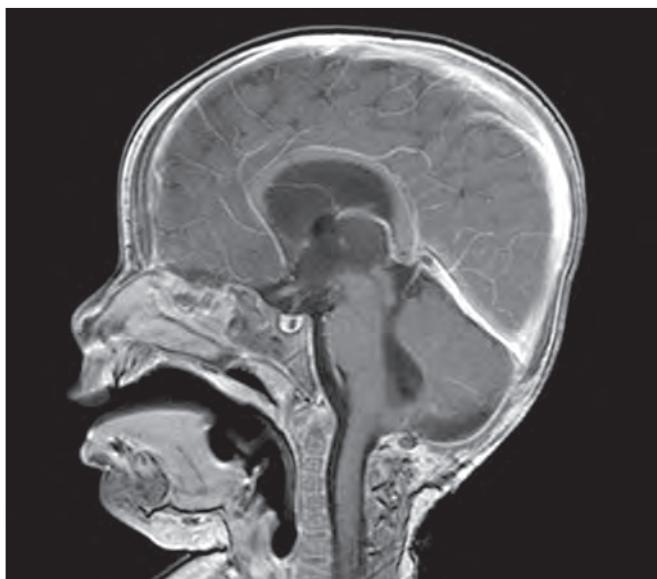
Postoperative sagittal MRI section.
